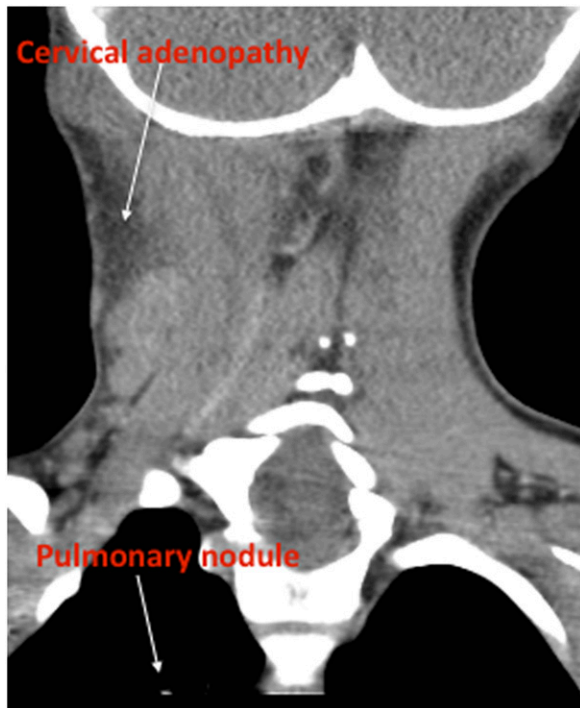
Case 2: computed tomographic scan of the neck showing extensive suppurative right cervical adenitis and a pulmonary nodule in the apex of the right lung.
